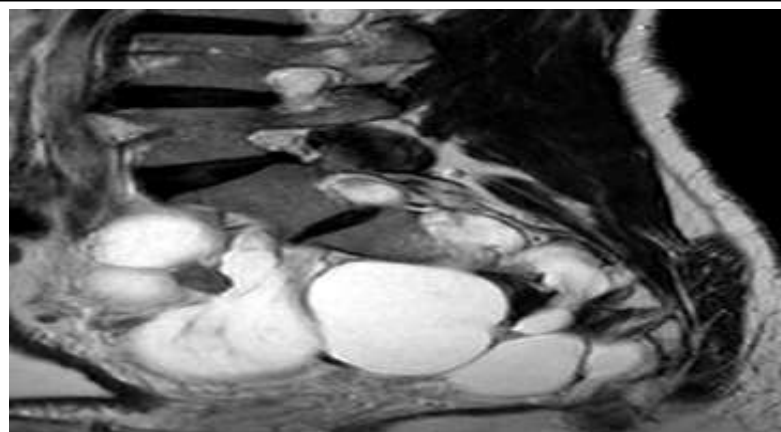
Sagittal T2 MRI Showing giant multiloculated presacral cyst (11×9 cm) extending through sacral foramina and neural foramina at L4–L5 and L5–S1, consistent with Tarlov cyst morphology
